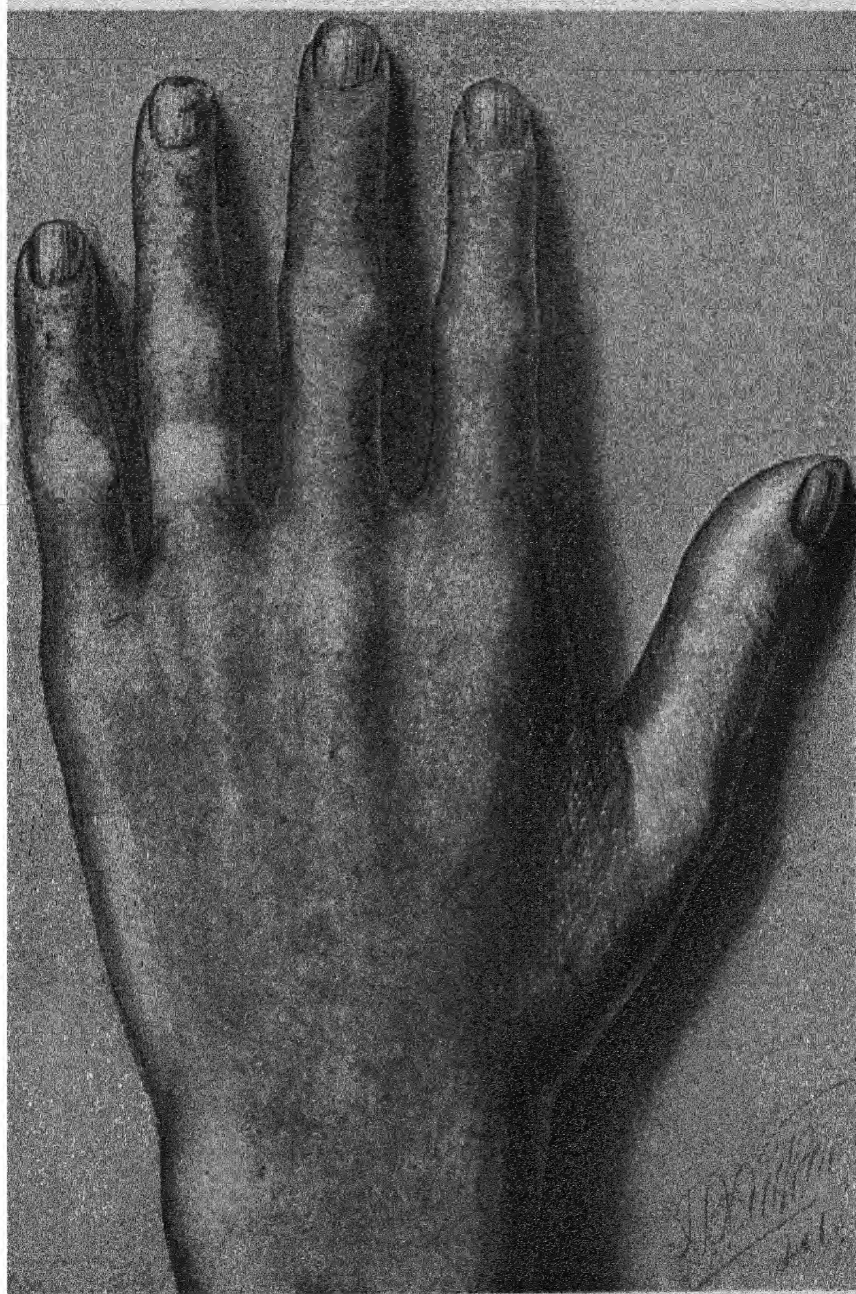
RESULT OF CHRONIC X-RAY DERMATITIS.
